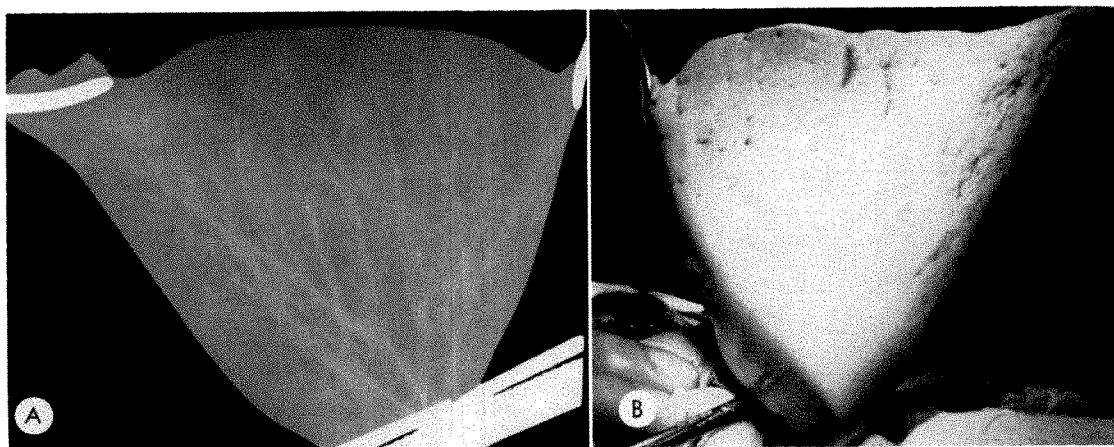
Roentgenogram (*A*) and photograph (*B*) demonstrate complete aeration of the total lobe. This resulted from cycled respiration at 40 cm. of water pressure through a single patent segmental bronchus for a period of five minutes.
